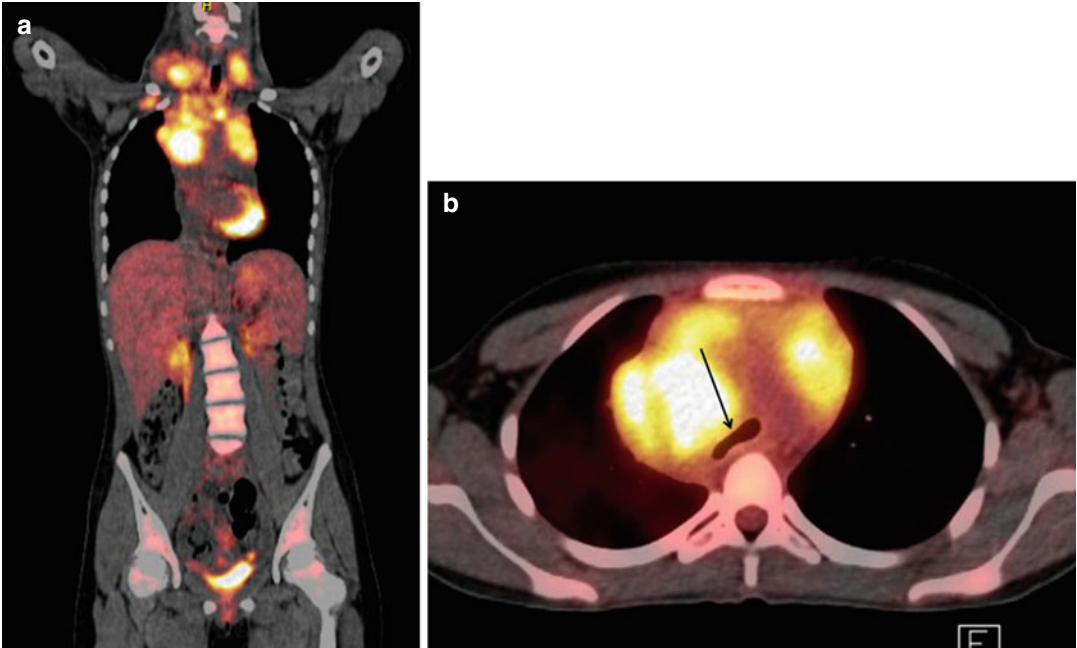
(a, b) PET/CT scan (a coronal reformat, b axial) detected the presence of disseminated nodal disease in cervical, supraclavicular, subclavian (SUVmax of 6.2), and mediastinal area (SUVmax of 10.7). Severe compression to the trachea was also noted (*arrow in b*)
